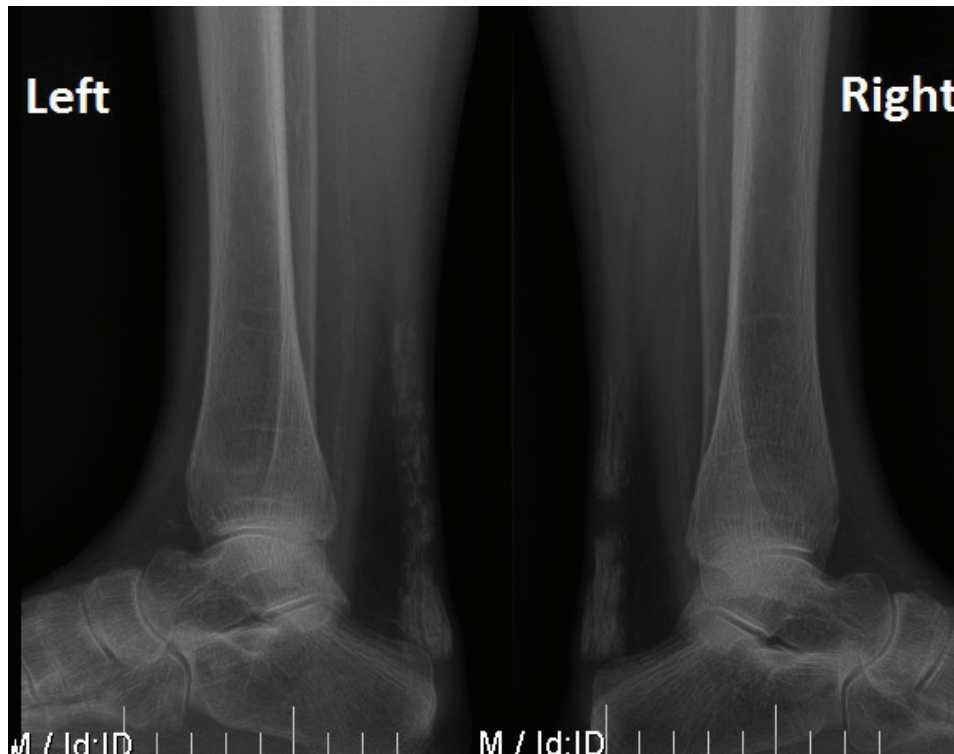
X-rays taken preoperatively showing massive ossification in both Achilles tendons.
